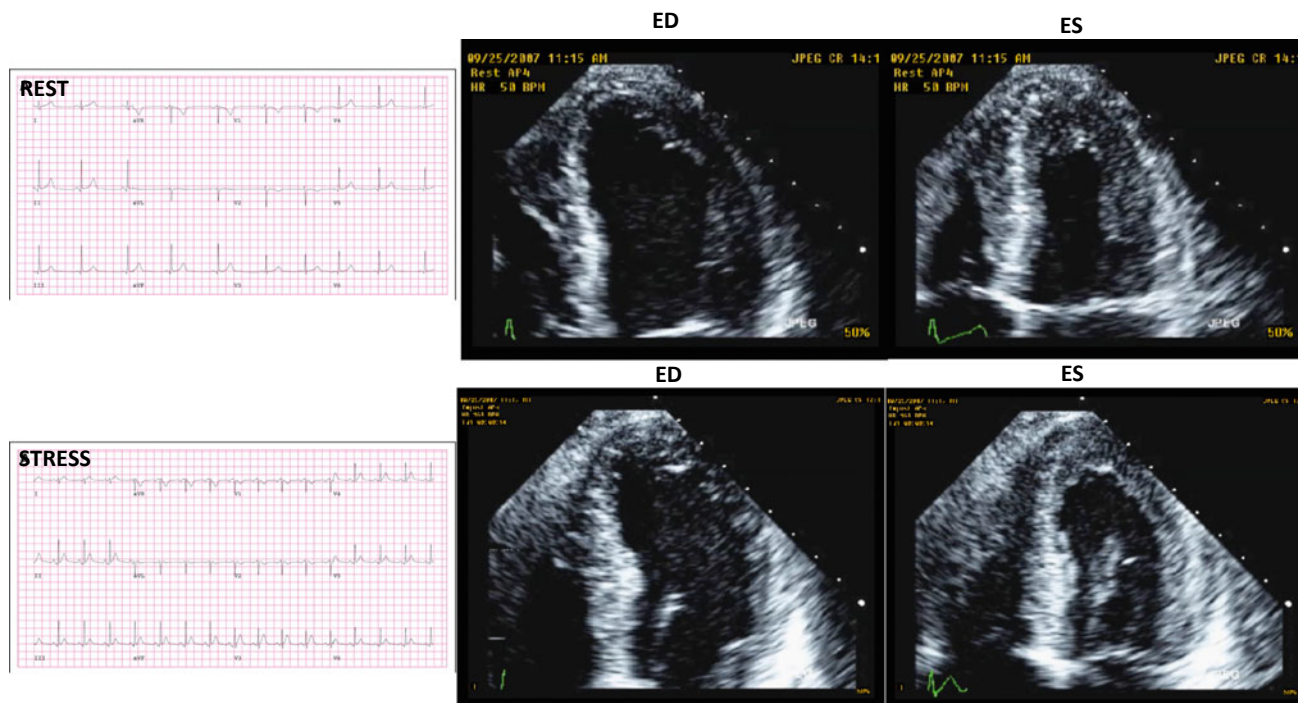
End diastolic (ED) and end systolic (ES) frames from echocardiographic apical four-chamber rest and stress studies showing apical wall motion abnormality with a decline in LV EF with exercise.
